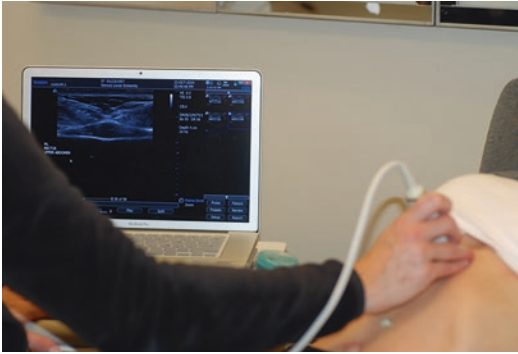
Routine preoperative ultrasonic evaluation of the abdomen in a 57-year-old patient to rule out any fascial defects or other abnormalities before abdominoplasty
